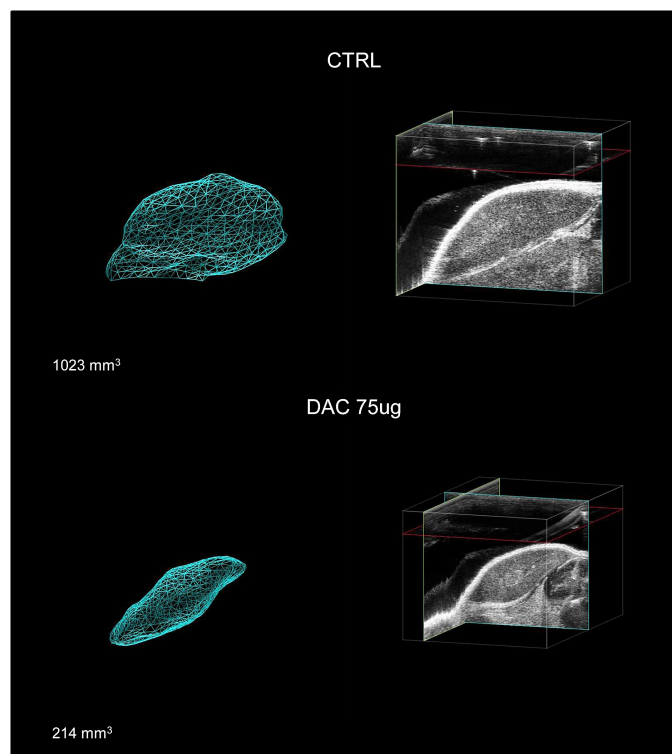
Weri-Rb1 xenografts. 3D ultrasound imaging of CTRL and DAC-treated xenografts.
